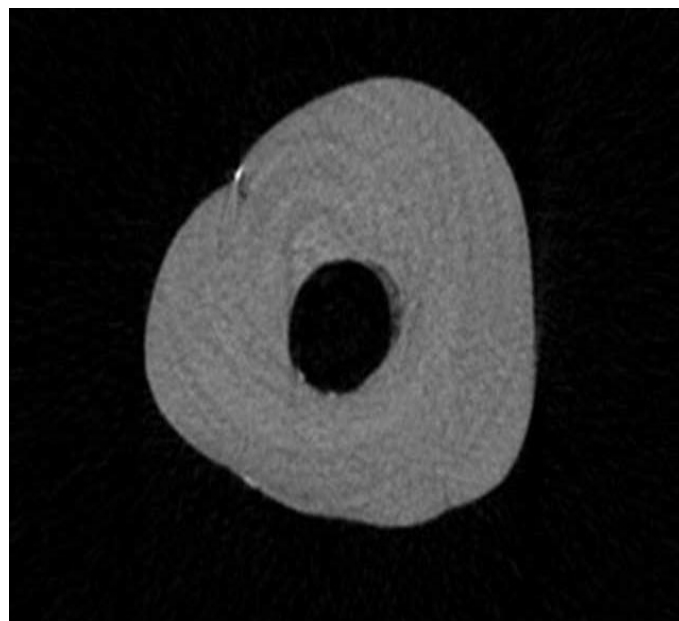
Micro-computed tomography imaging of the root with post volume analysis.
